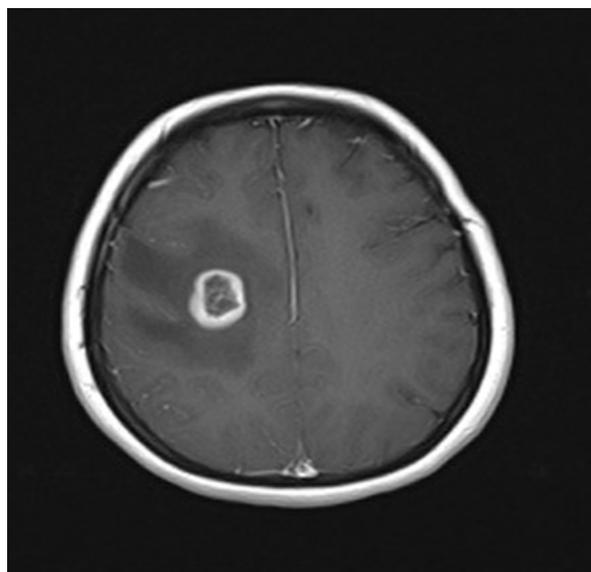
Brain MRI with contrast, showing right parietal lobe mass with ring enhancement.
